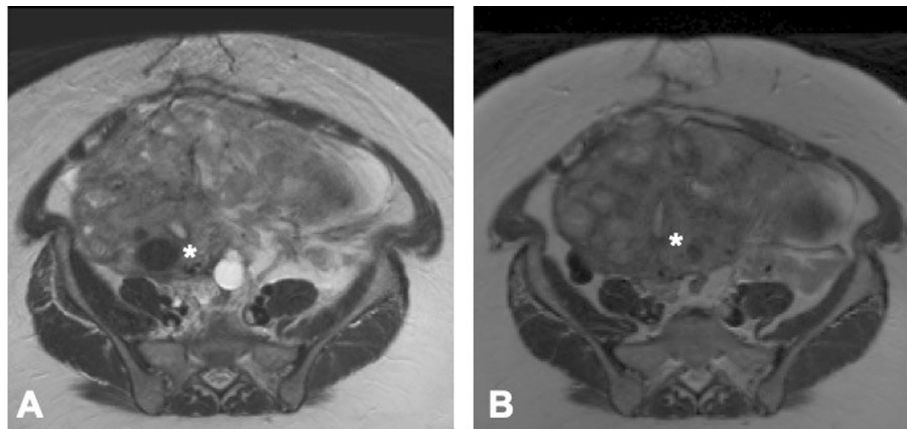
Axial T2W MRI in 2013 (A) and 2015 (B) showing a large soft tissue mass centred on the uterus (\*). Maximum axial dimension in 2013 was  $24.2 \times 13.9$  cm compared with  $22.4 \times 12.2$  cm in 2015.
